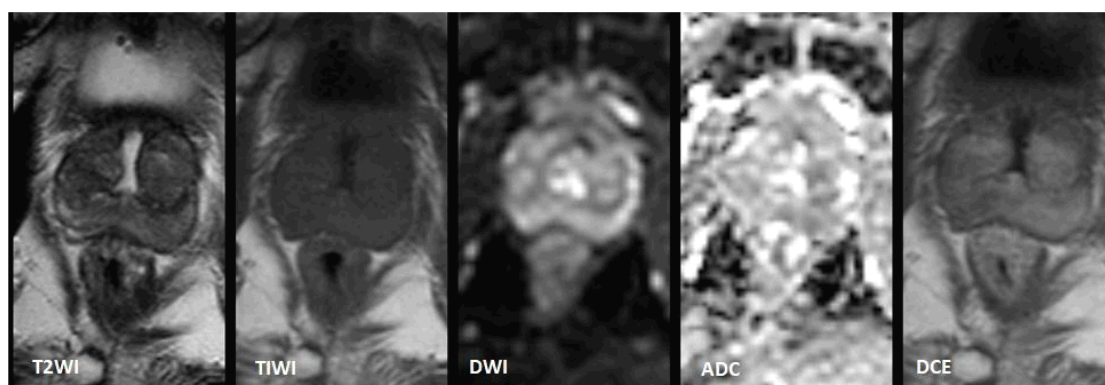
A localized lesion was found in the right anterior mid-peripheral zone of a 69-year-old male patient. He demonstrated mild/moderate DWI hyperintensity, T2W hypointensity, minor ADC hypointensity, and negative DCE (PI-RADS-3).
